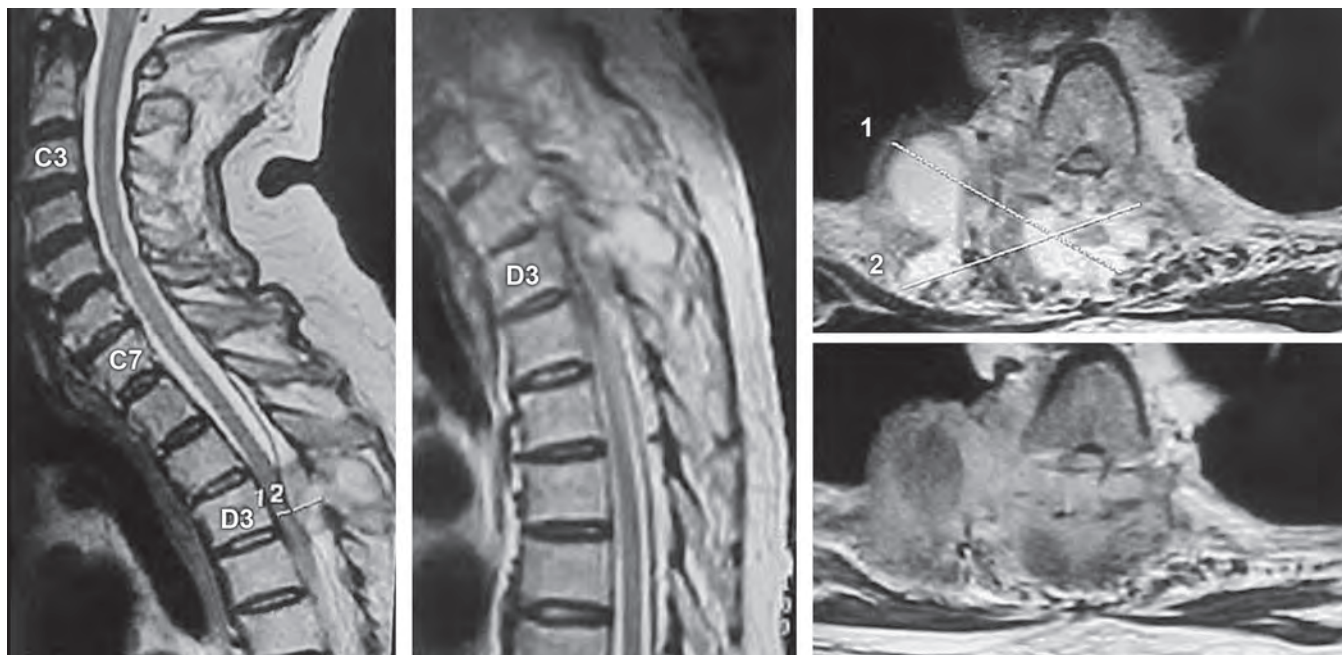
Sagittal MRI scan showing apendicular dorsal caries at D3 with dorsal epidural collection causing cord compression. Axial MRI T1-weighted and T2-weighted images showing the extent of involvement of the posterior elements
